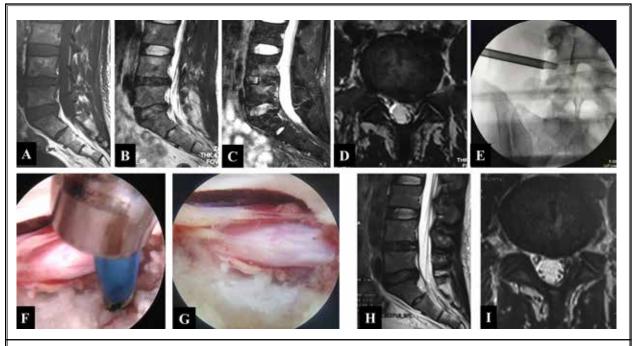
Preoperative T1-weighted sagittal (A), T2-weighted sagittal (B), fat-suppressed sagittal (C), and axial (D) MRI of a woman aged 36 years who complained of left leg radiating pain, showed L4-5 disc herniation with Modic type 1 signals in the bone marrow. Intraoperative radiography showed an endoscopic working channel (E). Intraoperative endoscopic view showed the herniated disc was removed, and the left L5 nerve root was decompressed completely (F-G). Postoperative T2-weighted sagittal (H) and axial (I) MRI showed the decompression of nerve root and removal of the herniated disc at the L4-5 level.
